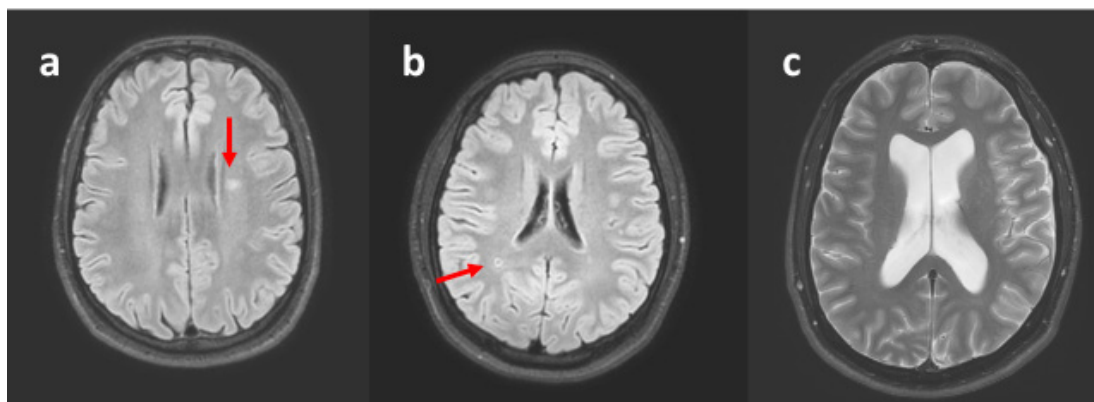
Examples to the brain magnetic resonance images of the patients with overt lesions on routine evaluation. a. FLAIR sequence, axial section, arrow depicting a hyperintense lesion adjacent to the left lateral ventricle in a 36-year-old man. b. FLAIR sequence, axial section, arrow depicting a right parietal lacune in the white matter in an 18-year-old boy. c. T2-weighted axial section showing hydrocephalus in a 32-year-old man.
